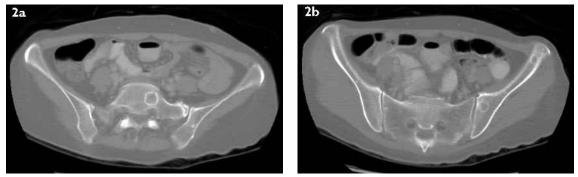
(a) Axial CT image of the pelvis (bone setting) shows ring-shaped lucency with sclerotic rim within the L5 vertebral body. (b) Axial CT image of the pelvis (bone setting) shows two ring-shaped lucencies with sclerotic rim within the left iliac bone.
